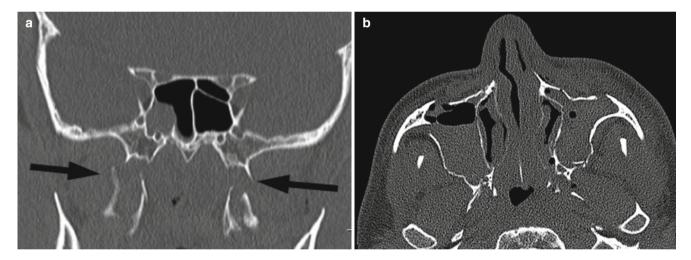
Fracture of the pterygoid plates (arrows) seen on CT (a, b)
